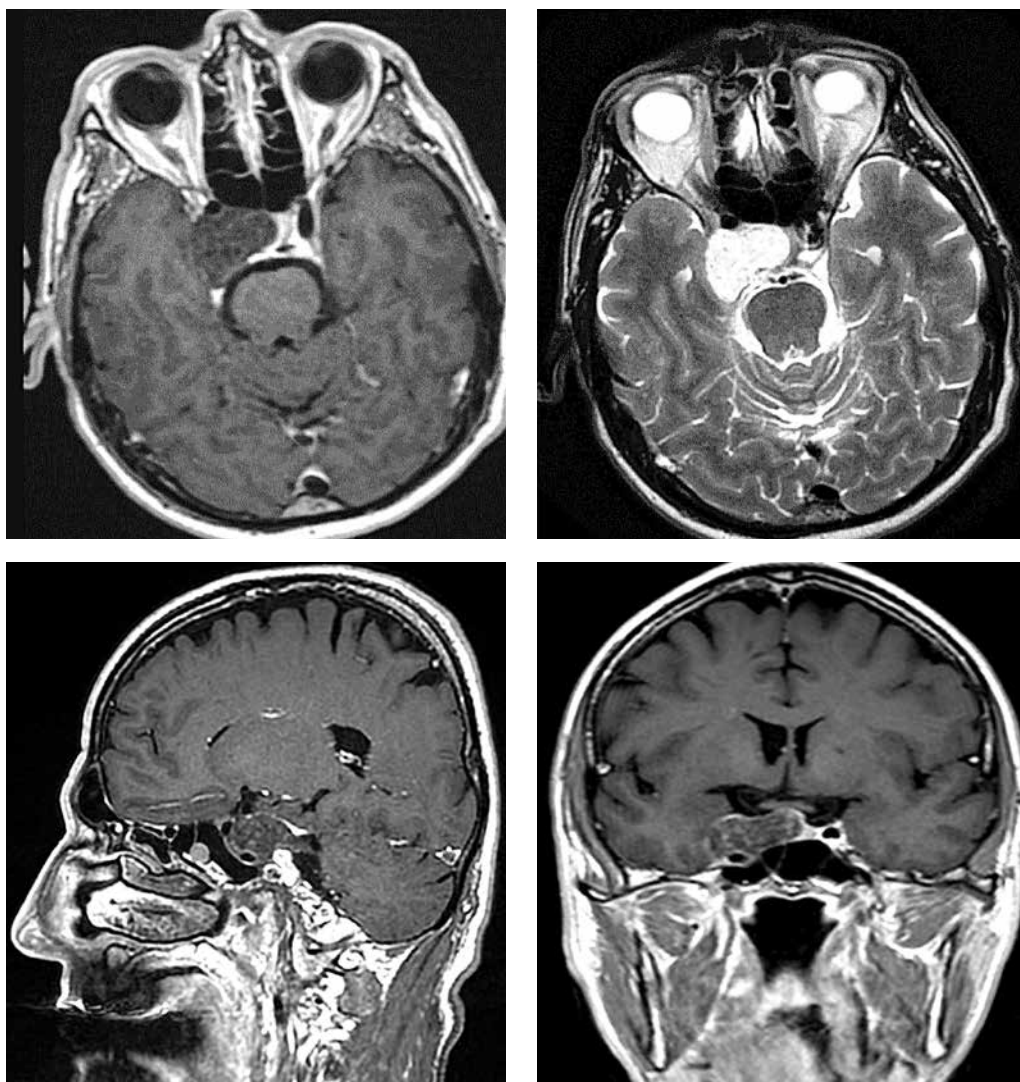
Magnetic resonance imaging of patient S. prior to surgery. In T1-weighted images, the lesion has homogeneous isointense signal. In T2-weighted and FLAIR images, the signal is hyperintense and also homogeneous. Contrast agent accumulation is inhomogeneous
